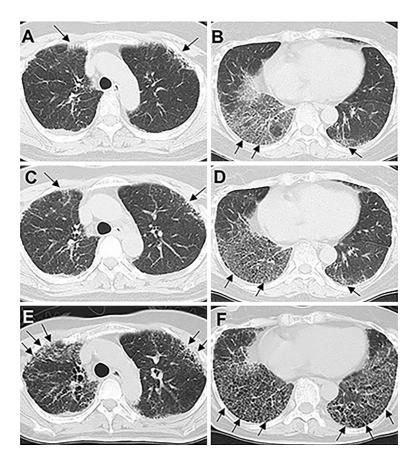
Changes in computed tomography (CT) findings after administration of pirfenidone. (A, B) CT images acquired at the start of treatment with pirfenidone show ground-glass opacities and reticular shadows in the peripheral regions of both lungs (arrows). (C, D) After 15 months of treatment with pirfenidone, the CT images indicate no further deterioration (arrows). (E, F) CT images obtained after 24 months of treatment with pirfenidone reveal progressive structural destruction and development of a honeycomb pattern in the peripheral regions of the upper and lower lobes in both lungs (arrows).
